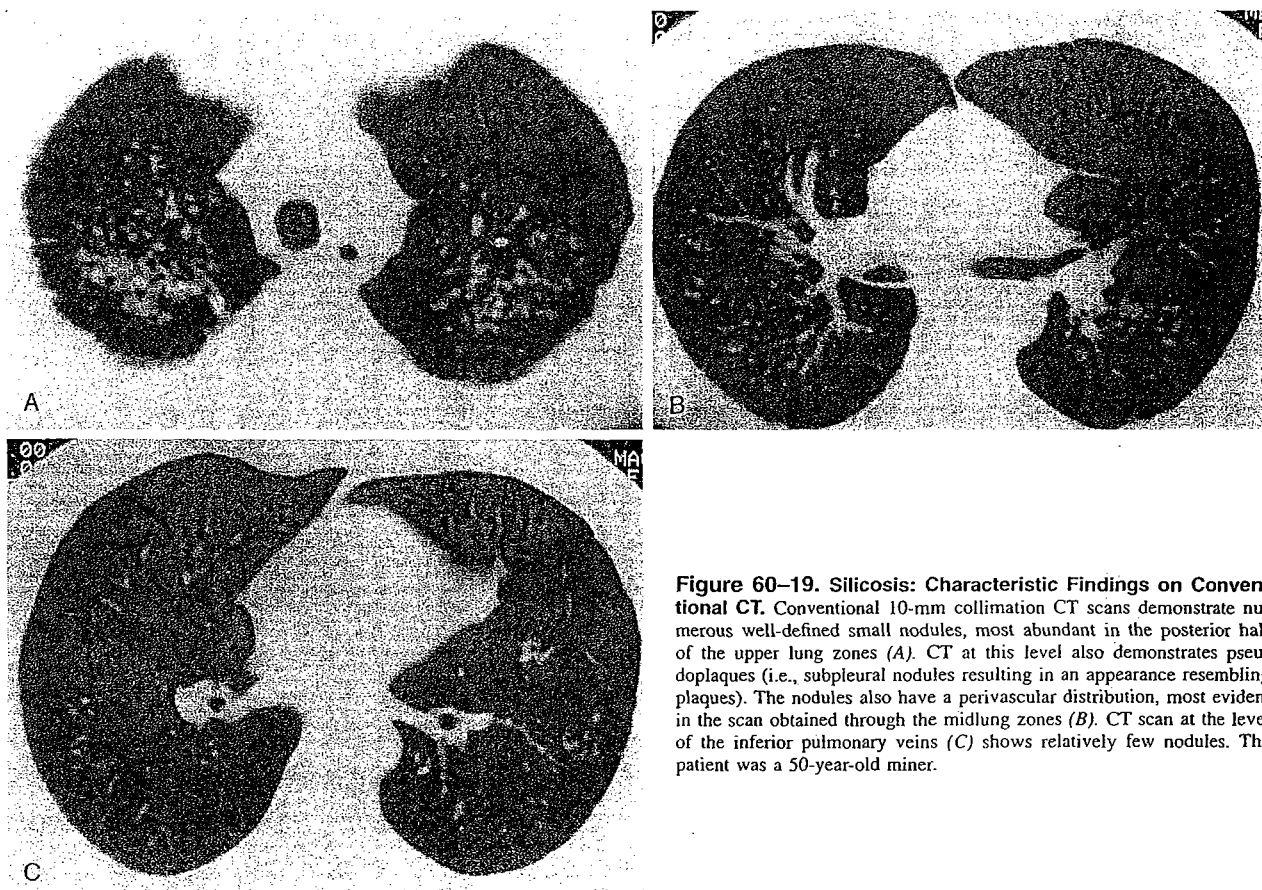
Silicosis: Characteristic Findings on Conventional CT. Conventional 10-mm collimation CT scans demonstrate numerous well-defined small nodules, most abundant in the posterior half of the upper lung zones (A). CT at this level also demonstrates pseudoplaques (i.e., subpleural nodules resulting in an appearance resembling plaques). The nodules also have a perivascular distribution, most evident in the scan obtained through the midlung zones (B). CT scan at the level of the inferior pulmonary veins (C) shows relatively few nodules. The patient was a 50-year-old miner.
